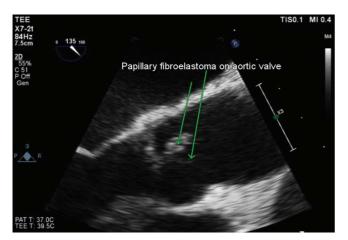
Papillary fibroelastoma on aortic valve visualized on mid-esophageal transesophageal echocardiography window. Image courtesy of Anthony Koppula, MD, and Robin Wachsner, MD, Division of Cardiology, Department of Medicine, Olive View–UCLA Medical Center, Los Angeles, CA.
